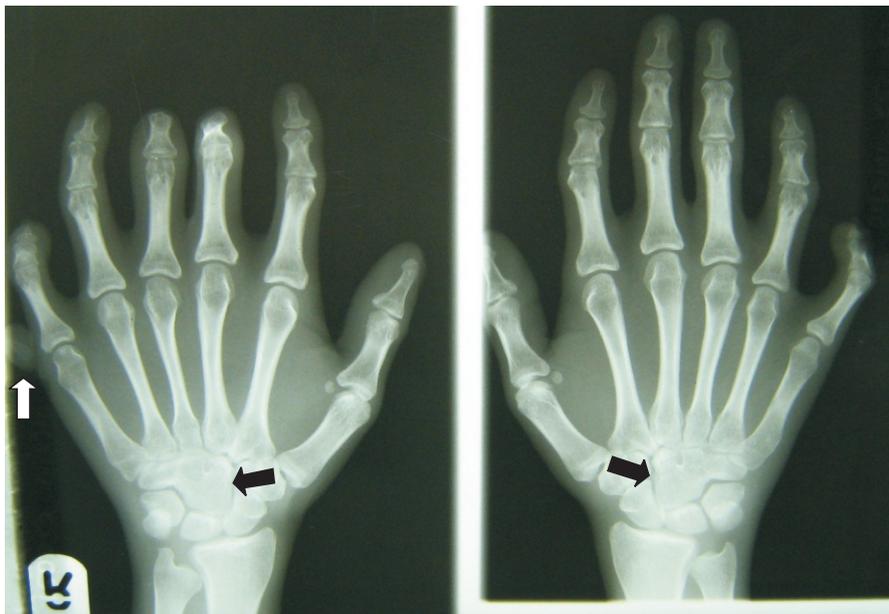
Plain radiographs of the hands showing six digits with a seventh hypoplastic one attached to the sixth, post-axially, on the right hand (white arrow). The middle phalanges in the 3rd and 4th digits on the right are absent. The left hand showed six well developed digits. Note the fusion of the hamate with capitate in both hands (black arrows).
